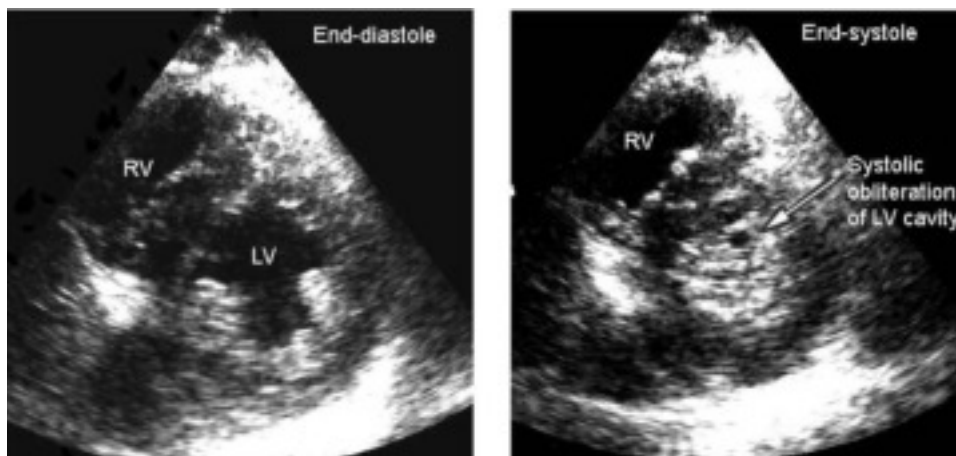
Systolic obliteration of the LV in a patient with severe LV hypertrophy and dehydration. This transthoracic, parasternal, short-axis view shows the LV at end-diastole (*left*) and at end-systole (*right*). Nearly complete obliteration of the LV cavity is seen at end-systole. Systolic obliteration of the CSA accompanies decreased end-diastolic area and is considered to be a sign of severe hypovolemia. In this case, the patient presented with hypotension and was found to be severely dehydrated because of a viral gastroenteritis.
